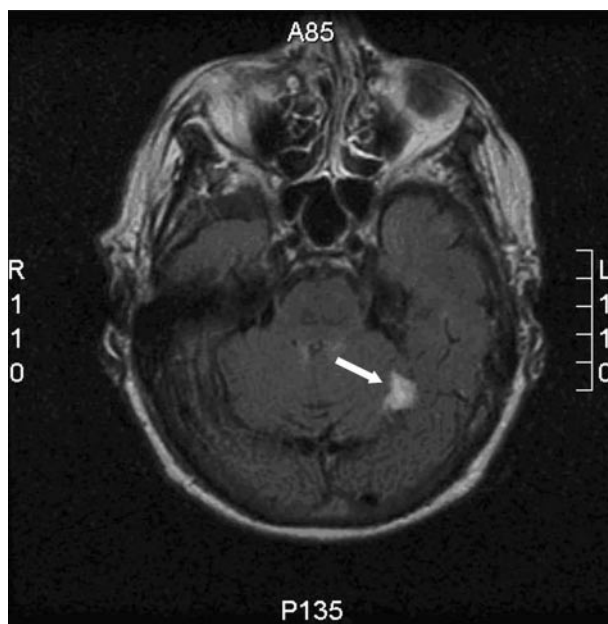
Magnetic resonance imaging scan of the case patient showing a dural-based lesion at the left tentorium leaflet (arrow).
